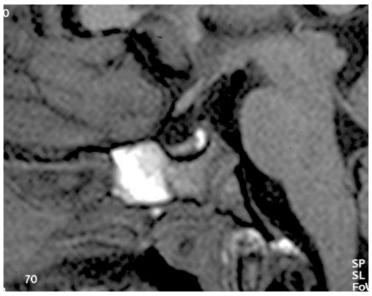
MRI patient Melibeyev S., 14 years
